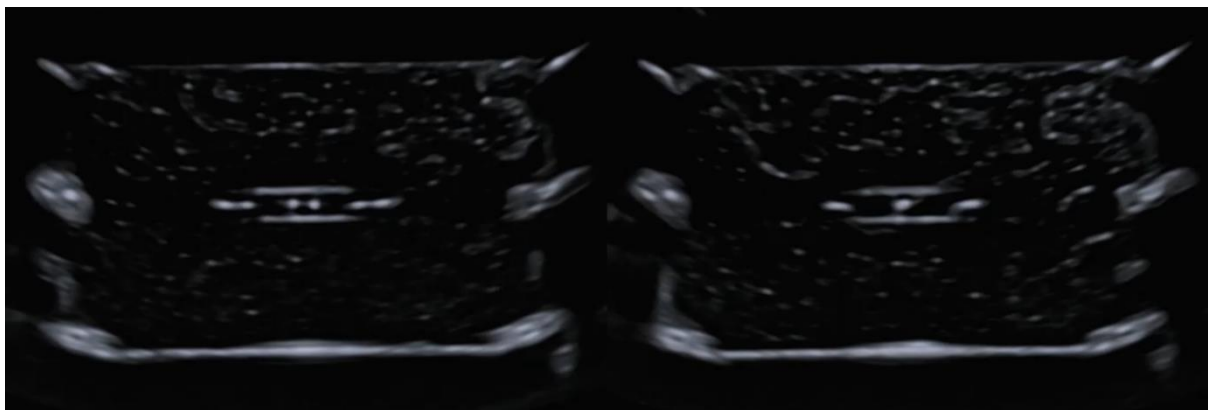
Ultrasound image of the second arrangement of wires. Left, the individual wires can be seen as 6 bright dots when the imaging plane intersects them. Right, the 3 pairs of wires coalesce into 3 dots as the imaging plane moves to the central position where the wires intersect.
